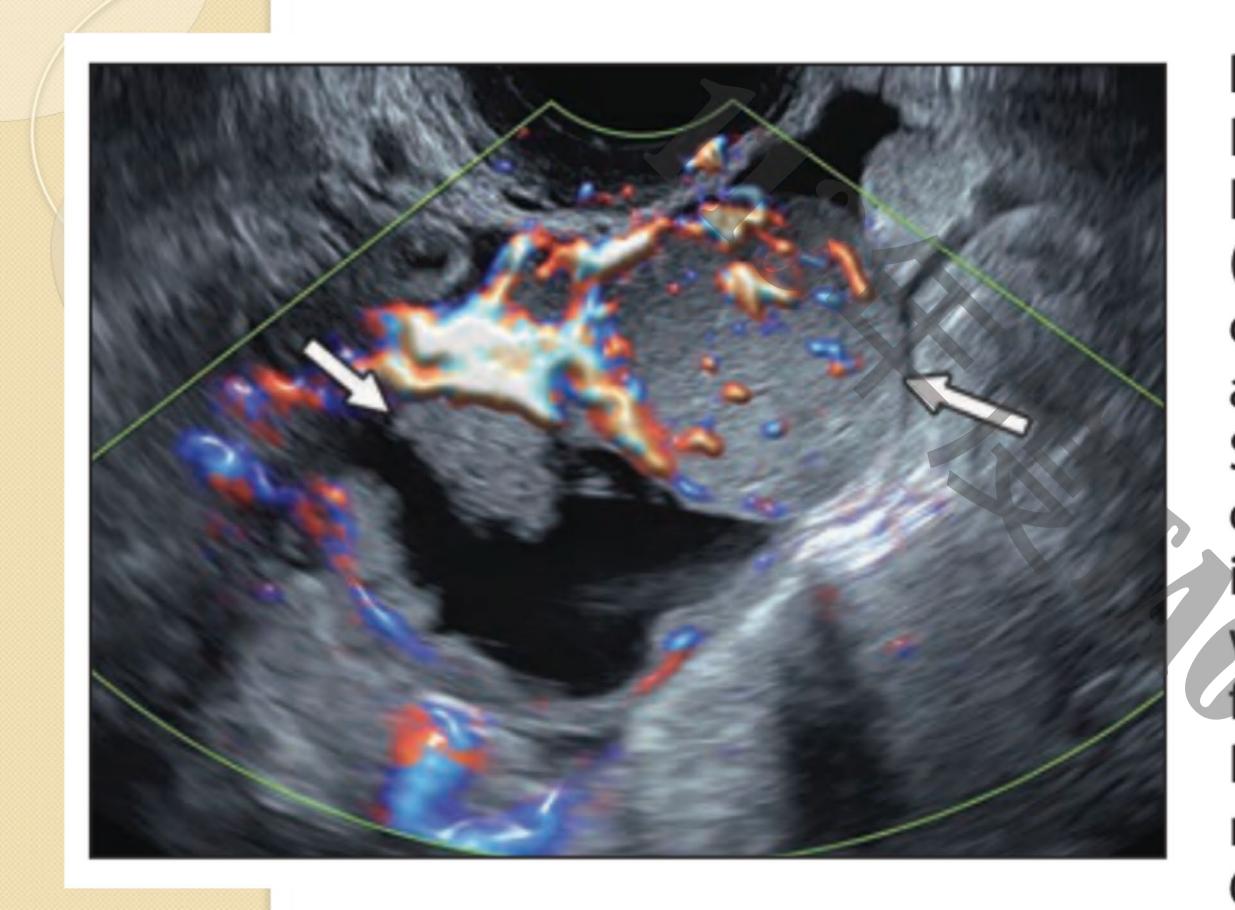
67-year-old woman with weight loss. Color Doppler ultrasound image shows multilocular cystic lesion with large, solid, vascularized components (arrows) proven to be high-grade serous tubal carcinoma. Color score (CS) is important for appropriate Ovarian-Adnexal Reporting and Data System (O-RADS) categorization of multilocular cystic lesions with solid components. Color Doppler imaging shows very strong flow (CS 4) consistent with O-RADS category 5 lesion. Size is irrelevant for risk stratification of lesions with these features. Distinction between papillary projection and nonpapillary solid component is not relevant for O-RADS categorization of multilocular cystic lesions.
